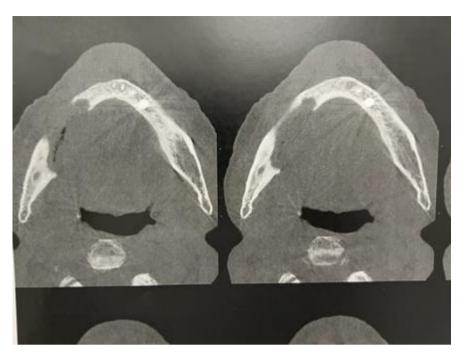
CBCT axial reconstruction showing the lytic bone destruction of lingual bone plate
